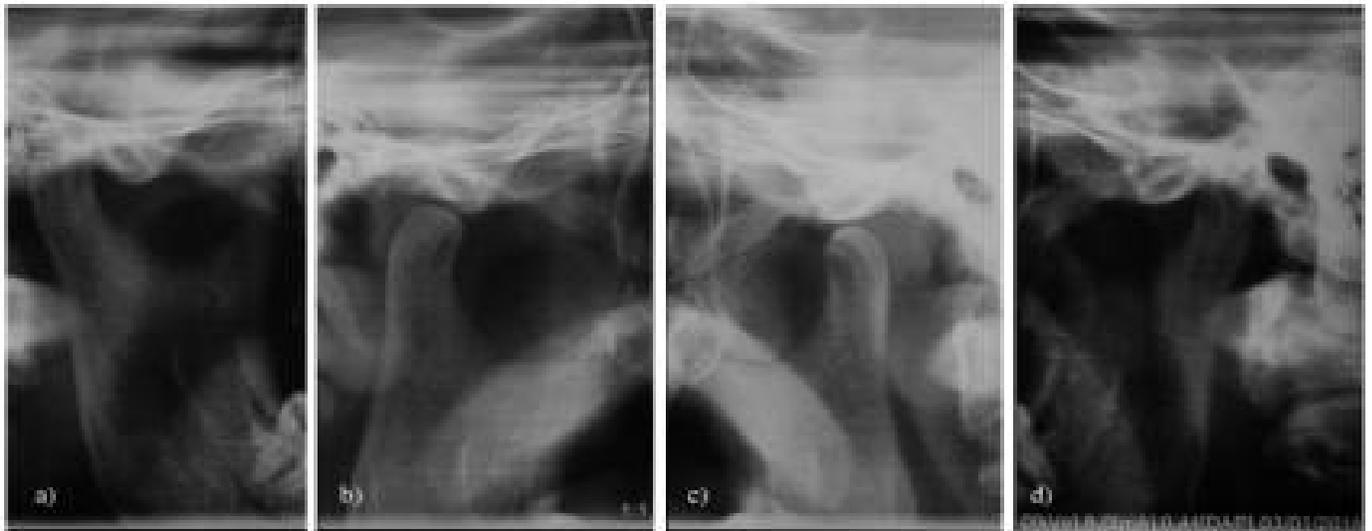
Panoramic radiography: important asymmetry between right and left mandibular condyle (Talmaceanu et al (a)2018).
